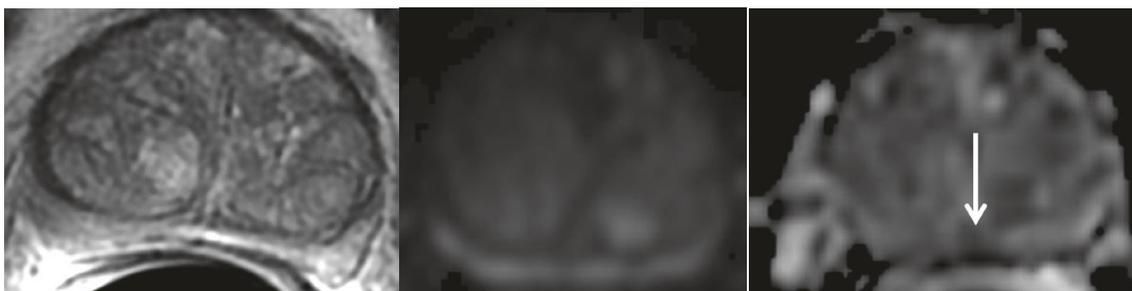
PI-RADS 2 category in PZ. First, T2WI. Second, b1400 DWI. Third, ADC map, without any focal lesion on DWI and a mild low signal intensity on ADC map (arrow) in the PZ. Obtained from (12).
